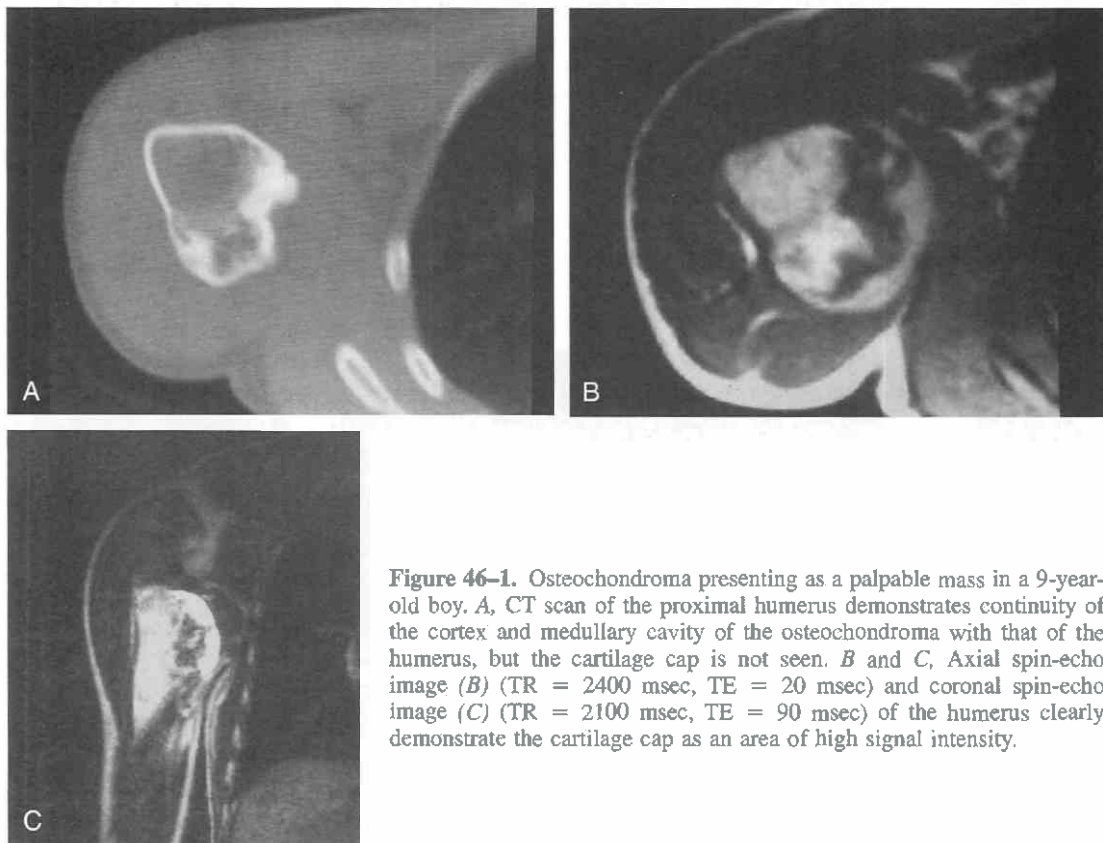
Osteochondroma presenting as a palpable mass in a 9-year-old boy. A, CT scan of the proximal humerus demonstrates continuity of the cortex and medullary cavity of the osteochondroma with that of the humerus, but the cartilage cap is not seen. B and C, Axial spin-echo image (B) (TR = 2400 msec, TE = 20 msec) and coronal spin-echo image (C) (TR = 2100 msec, TE = 90 msec) of the humerus clearly demonstrate the cartilage cap as an area of high signal intensity.
